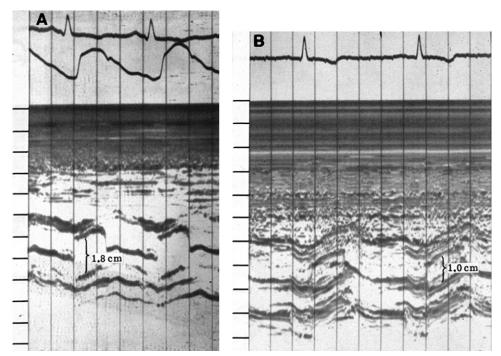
M-mode recordings of the aortic valve in a patient with a normal valve (A) and a patient with valvular aortic stenosis (B). Both valves produce a parallelogram on the M-mode tracing; however, the stenotic valve is more echogenic and the separation of the leaflets is reduced. Although this recording provides no quantitative information, it does confirm that if there is LV outflow obstruction, then the aortic valve is at least a contributor of, if not the sole reason for, the obstruction. (From Feigenbaum H. *Echocardiography*. 1st ed. Philadelphia, PA: Lea and Febiger; 1972.)
